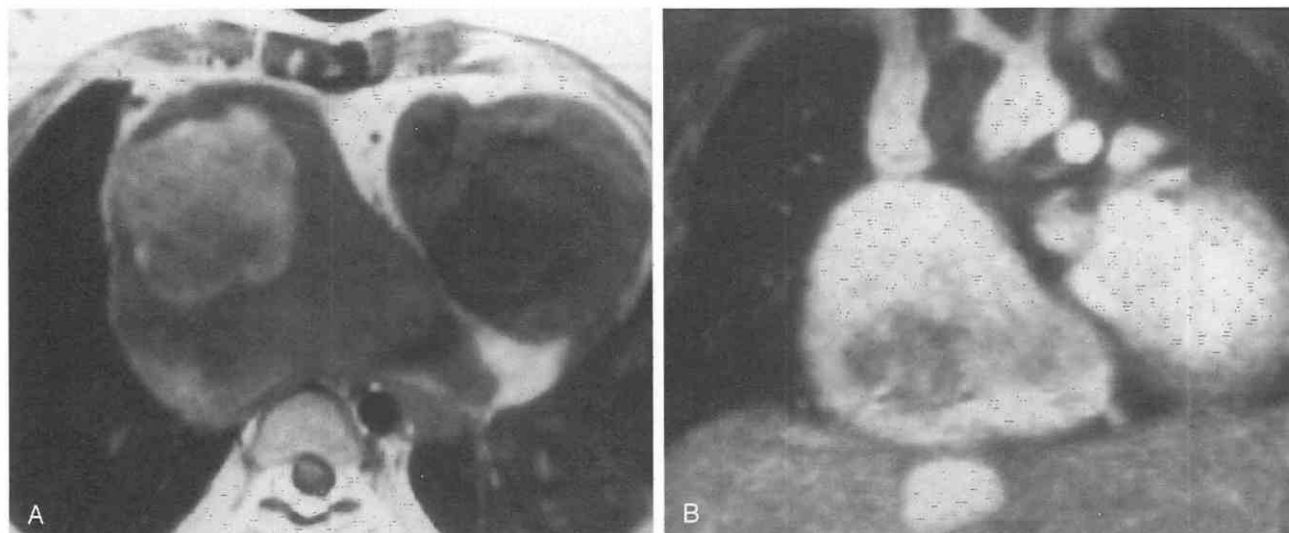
Tricuspid atresia and right atrial mass after a Fontan procedure in a 13-year-old girl. *A*, Unenhanced cross-sectional echocardiographic axial image shows a bright signal thrombus surrounded by slow flow. *B*, Coronal gradient-recalled echocardiographic image shows flow around the thrombus.
